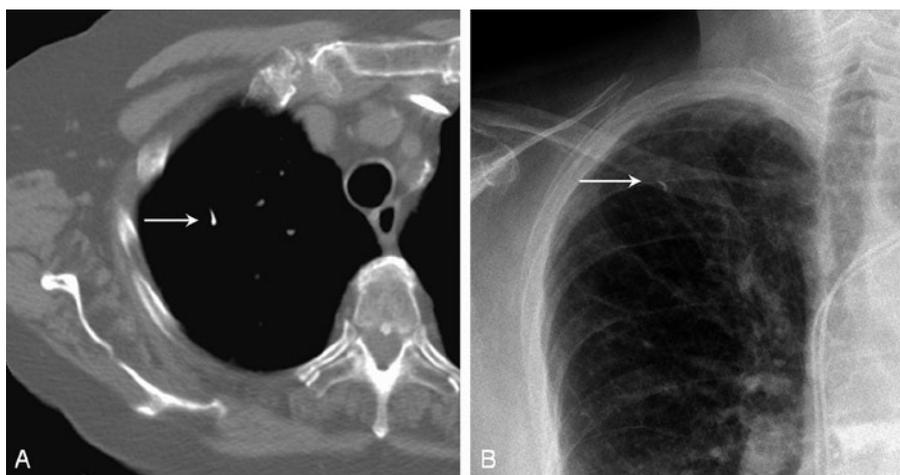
Small pulmonary PMMA embolus in right upper lobe visible on a native chest CT scan (a) and on a chest radiograph (b).
